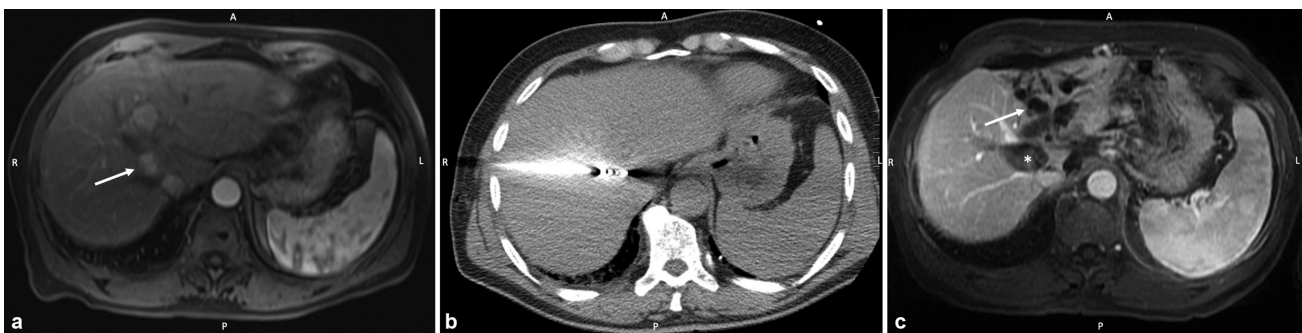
(a) Axial contrast-enhanced MRI of the liver which demonstrated hepatocellular carcinoma (HCC) in the right hepatic lobe (white arrow). (b) Axial image at the time of RFA of the HCC. (c) Axial contrast-enhanced MRI 3 months after ablation which demonstrated biliary obstruction of the left hepatic lobe bile ducts (white arrow). Asterisk indicates the ablated tumor.
